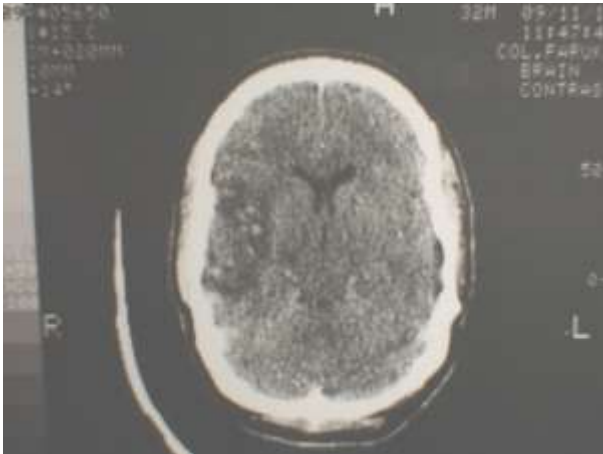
CT Scan brain after one-month showing right parietal lobe infarct.
